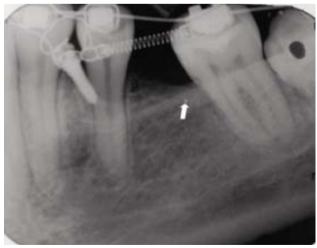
Periapical X-ray showing a punctiform (arrow) radiopaque image in the alveolar ridge, suggesting the presence of metallic material
